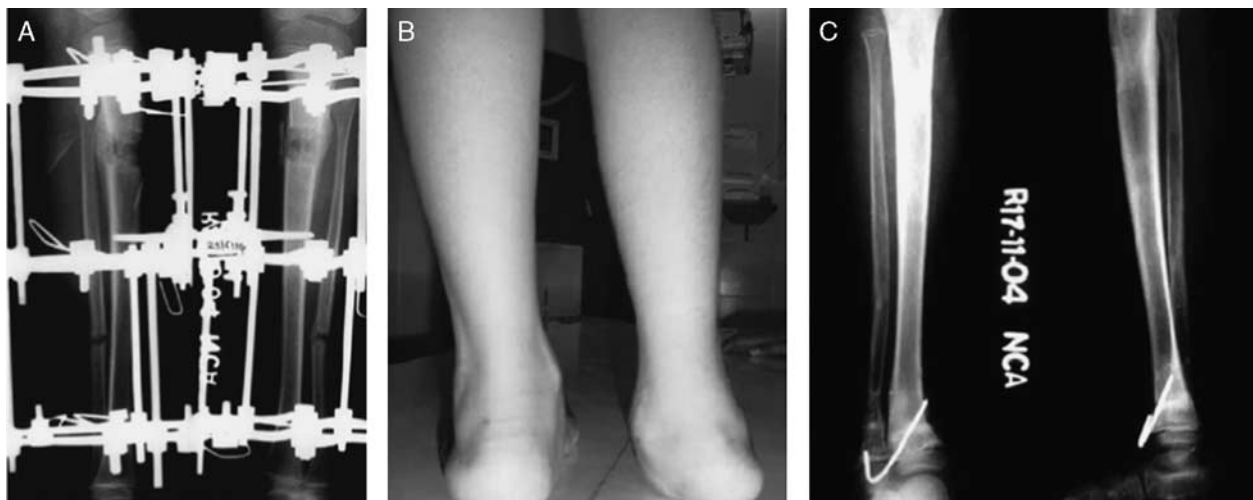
X-ray of the same patient as in Figure 3 after treatment with tibial lengthening using the Ilizarov method as an external fixator (A). Clinical picture showing dynamic equinovalgus at the ankle (B), corrected with supramalleolar osteotomy and k wire pinning (C).
